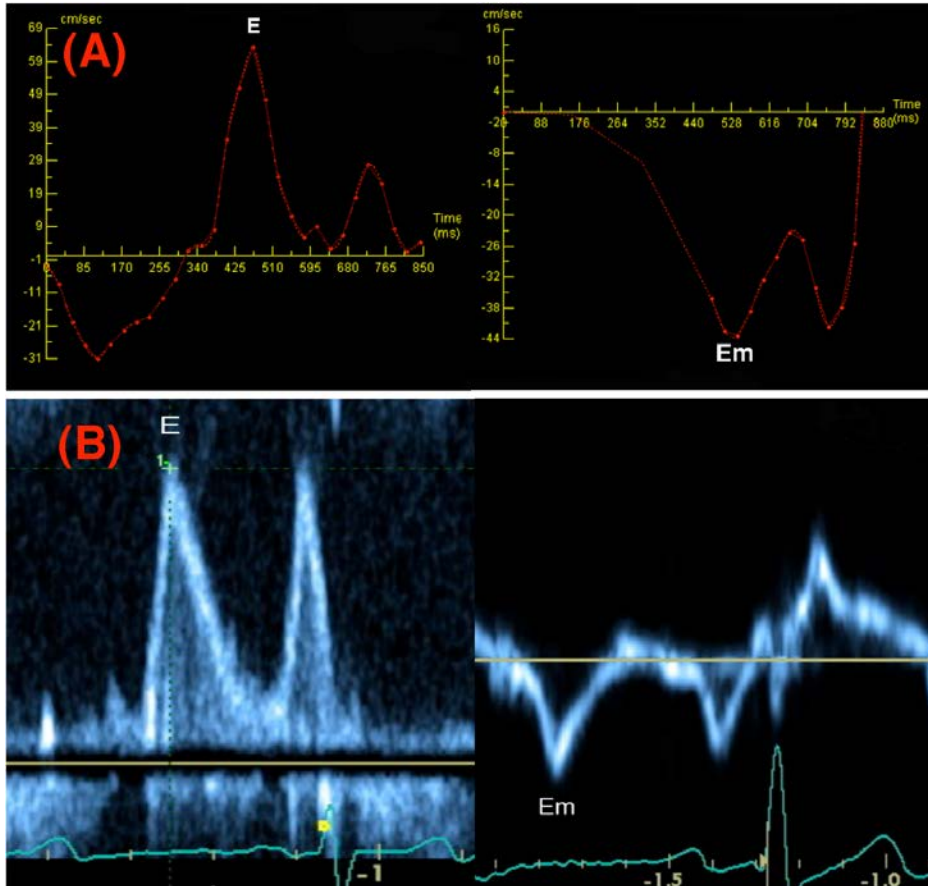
Calculating E/Em as a non-invasive estimate of LVEDP using (A) VEC-CMR (B) tissue Doppler echocardiography
